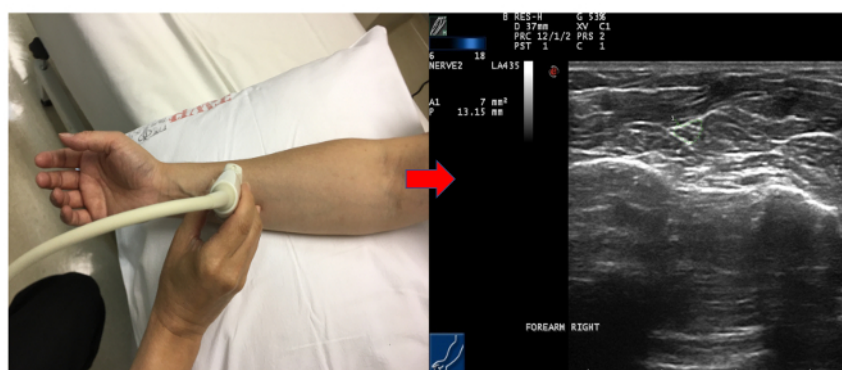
Measurement of the one-third distal forearm and its ultrasound imaging. [Please click here to view a larger version of this figure.](#)
